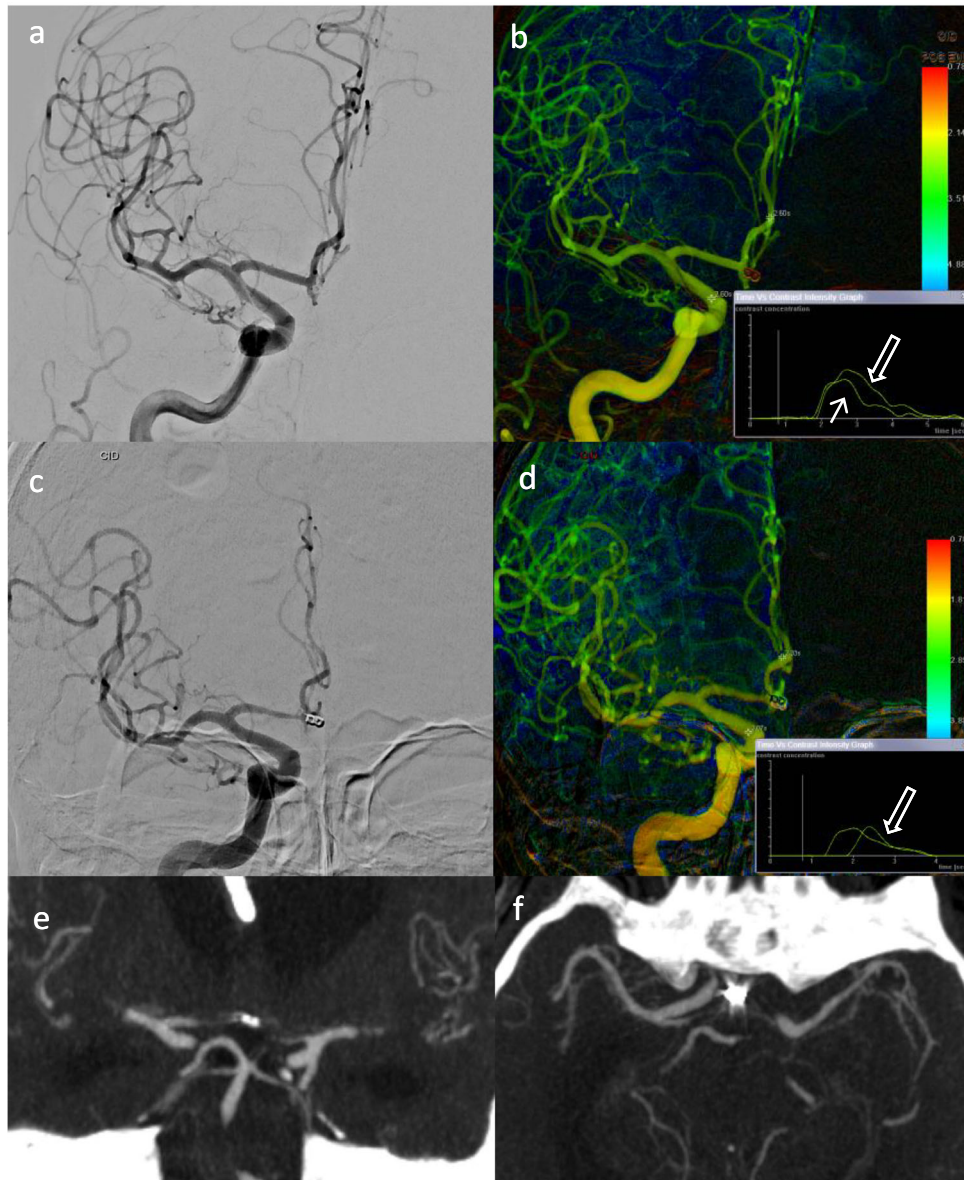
Thirty-six-year-old patient with a ruptured anterior communicating artery aneurysm. Admission DSA showed normal diameter of the arteries (a, right internal carotid artery injection, AP view). Colour-coded DSA images (b) show no delay in transit time between ICA and A1 at post-embolization period, as demonstrated by the time–contrast concentration curves with similar times measured in the internal carotid artery (white arrow) and in the A2 segment of the anterior cerebral artery (open arrow). At 15 days, moderate vasospasm of the A1 and A2 segments of the anterior cerebral artery are noted on DSA (c), with corresponding delay of contrast arrival at the A2 segment on the colour coded DSA images (open arrow) (d). A CTA performed on the same day (e, coronal; f, axial MIP reconstructions) showed similar vasospasm in the A1 segments bilaterally. Note how the presence of metallic artefacts originated from the aneurysmal coils impairs correct assessment of adjacent arteries (f)
